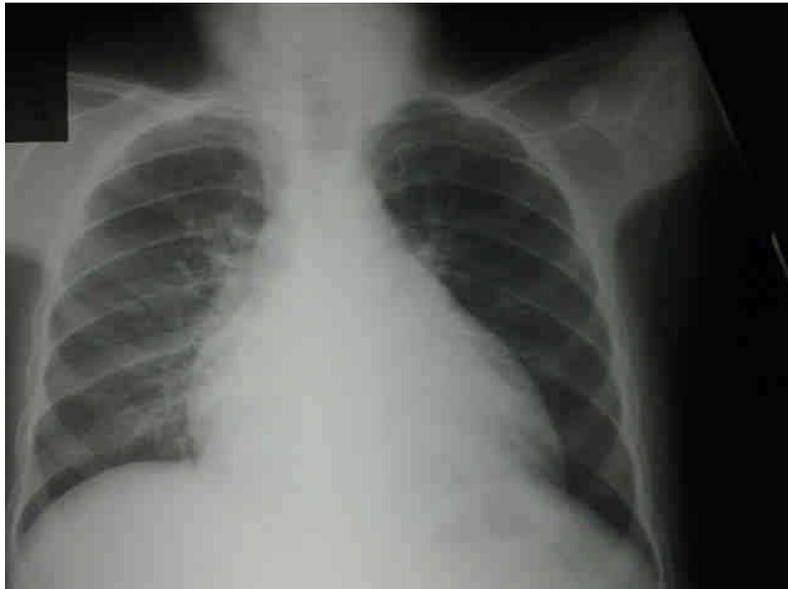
Chest X-ray showing cardiomegally in  $\beta$ -thalassemia major patient
